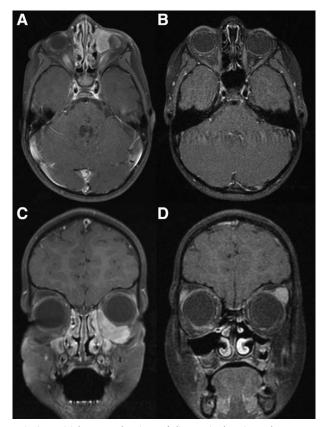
Initial MRI at the time of diagnosis showing a large enhancing mass in the inferomedial left orbit (A and C). Subsequent MRI showing resolution following orbital proton radiotherapy and chemotherapy (B and D).
